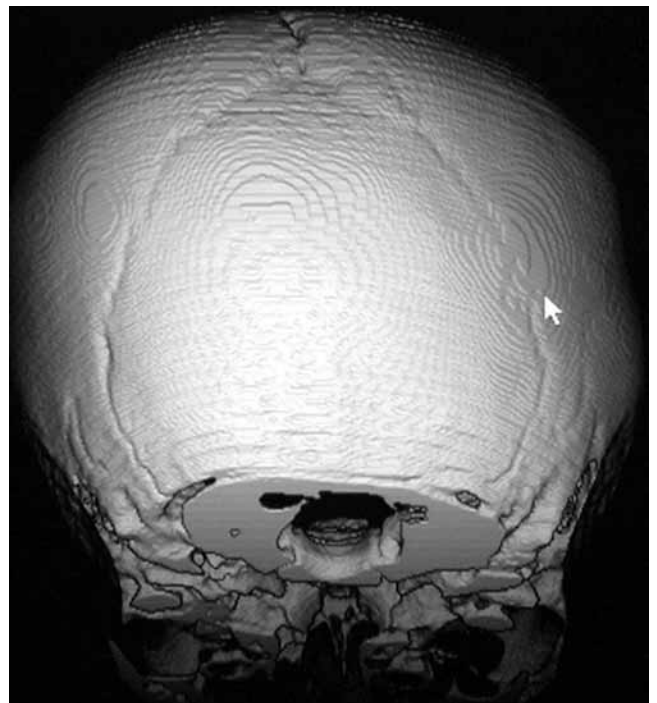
Posterior view of 3D CT of plagiocephalic skull.
